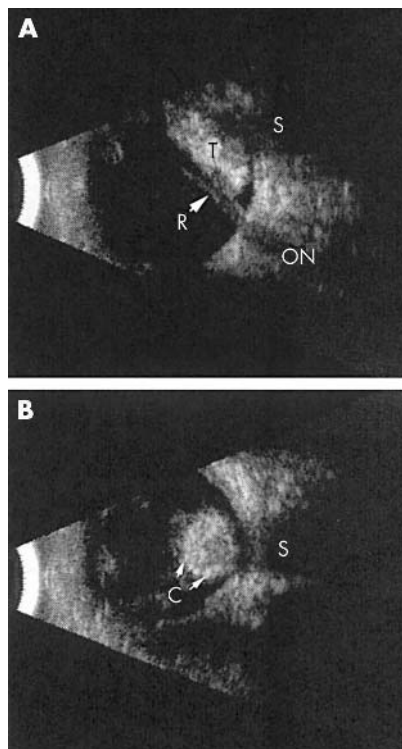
B-scan ultrasonography. (A) A longitudinal view of the right eye demonstrates a tumour posterior to a closed funnel retinal detachment. (B) A transverse view of the eye demonstrates a rounded, densely calcified tumour. R, retina; S, shadow in orbit; C, calcification; T, tumour; ON, optic nerve.
